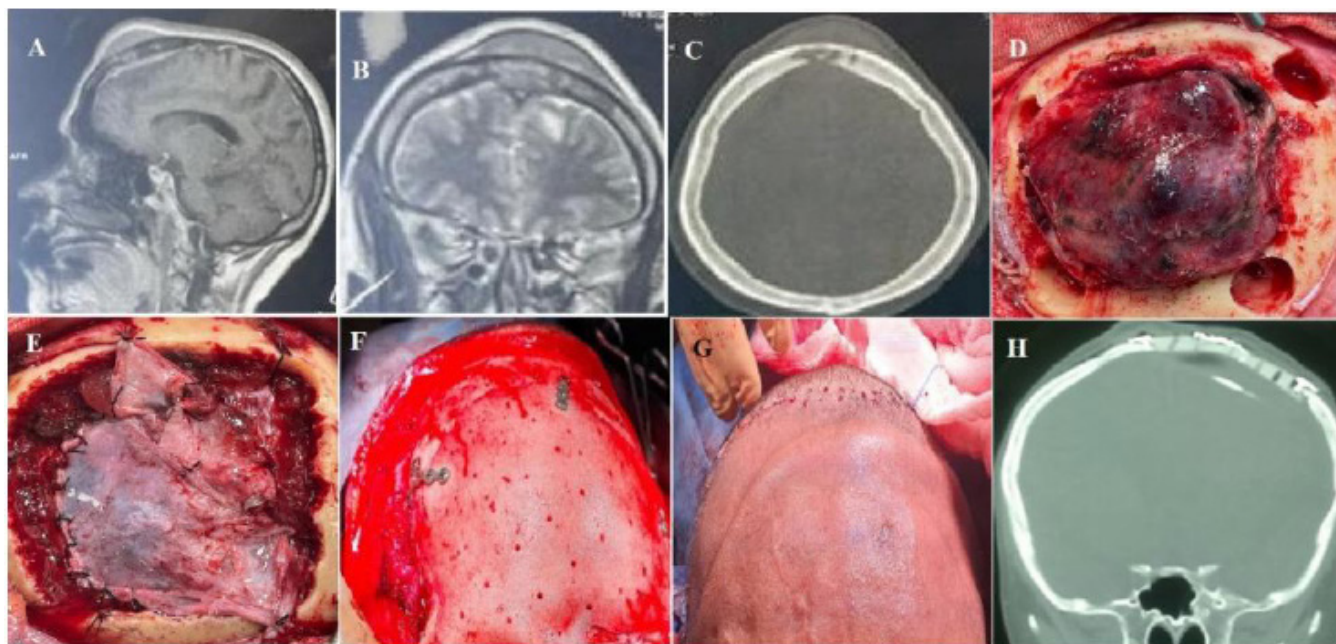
A) Sagittal MRI T1 WI with contrast showing enhanced frontal dura and a mass invading the bone and scalp layers. B) Coronal MRI T2 WI showing left frontal mass crossing to the other side with invasion of the scalp layers. C) Axial CT bone window image showing frontal bone erosion with extension of lesion to scalp layers. D) Intraoperative photo showing preparing for elevation of bone flap and obvious lesion amalgamated with galeal tissue. E) Intraoperative photo showing dural grafting after removal of pathological dura and bone flap. F) Intraoperative photo showing well positioned PEEK flap fixed with mini plates and screws and covering the bony defect completely. G) Intraoperative photo showing skin incision closure with staples after all layers closure over a subgaleal closed drainage system. H) Coronal CT bone window image showing good closure of the bony defect.
